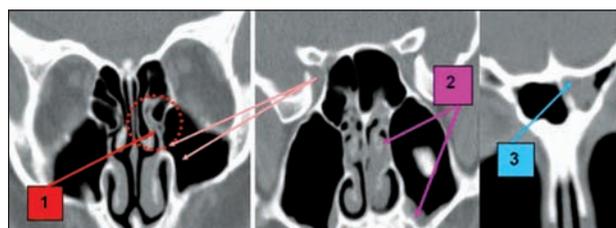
Paranasal sinuses CT scan, bone window, consecutive coronal slices: 1. pneumatized left uncinate process inserted into concha bullosa and ethmoid bulla, with narrowed uncinate sulcus; 2. left maxillary sinus and bilateral ethmoid sinus inflammatory process; 3. left frontal sinus inflammatory process
